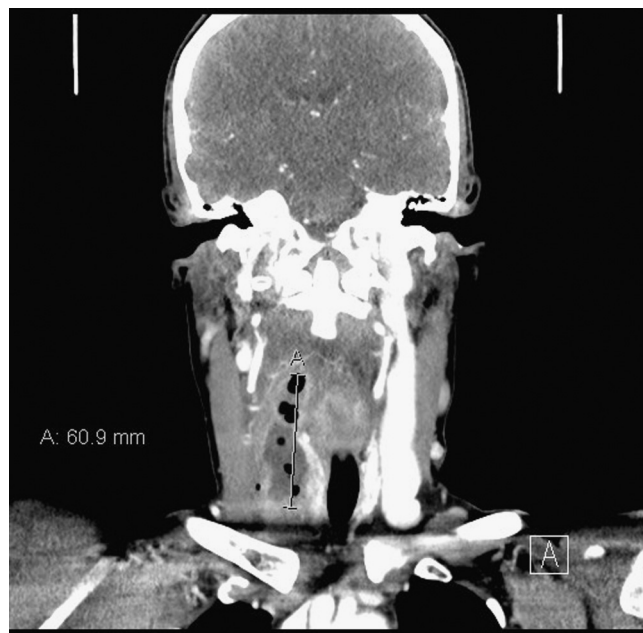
A coronal view CT scan with contrast of the thyroid cartilage, at the level of the pyriform fossa as well, showing the extent of the neck abscess inferiorly.
